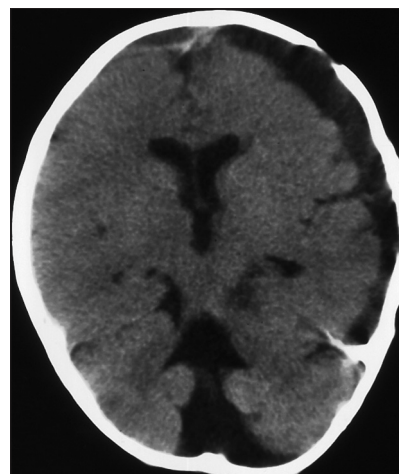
A postoperative axial CT shows adequate evacuation of the subdural hematoma
